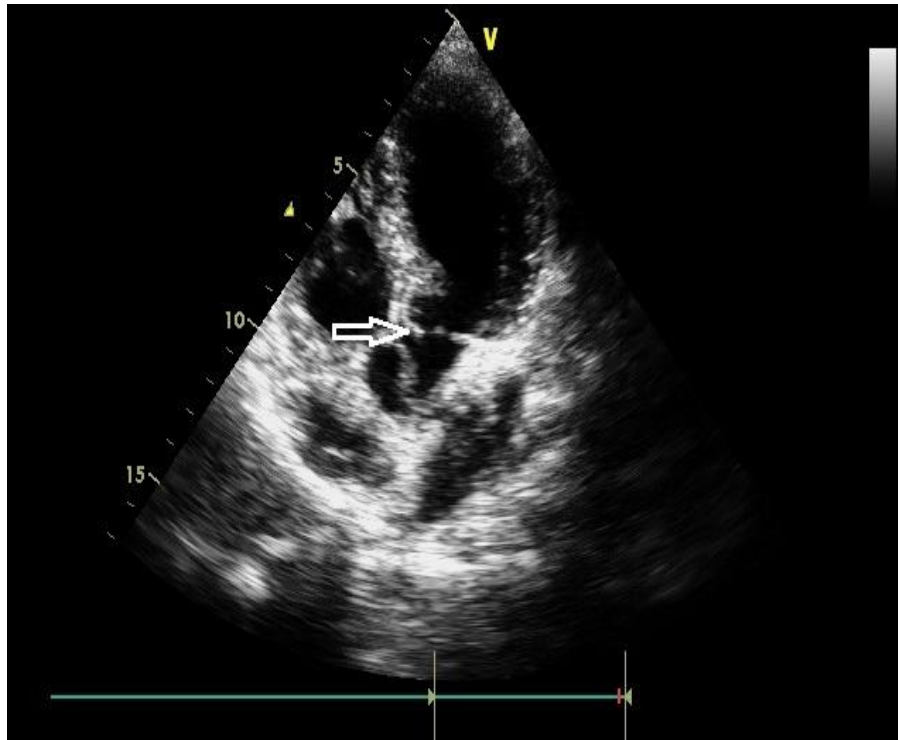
Echo- apical five chamber view showing membrane just below the aortic valve
